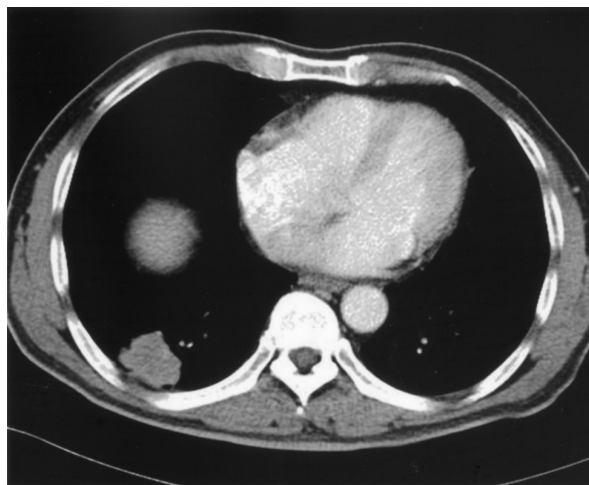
Contrast-enhanced chest CT scanning shows a mass lesion with soft tissue density and irregular margin. Adjacent pleural thickening was also noted.
